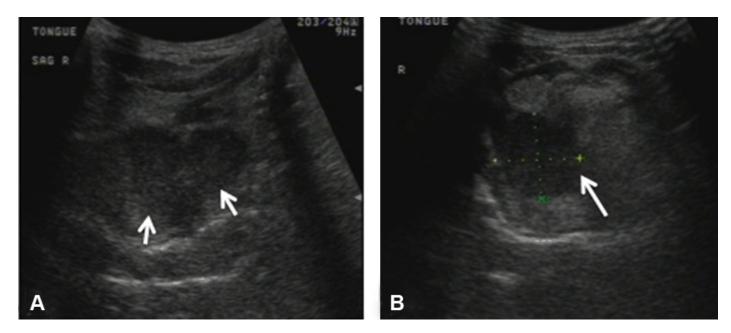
(A) Longitudinal ultrasound image showing a hypoechoic lesion involving the base of the tongue. The margins of the lesion (arrows) are scalloped and well delineated from the surrounding normal tongue, (B) Transverse plane showing a peripheral hypoechoic lesion which measured 2.5x2.3 cm (crosses) (Case 1).
